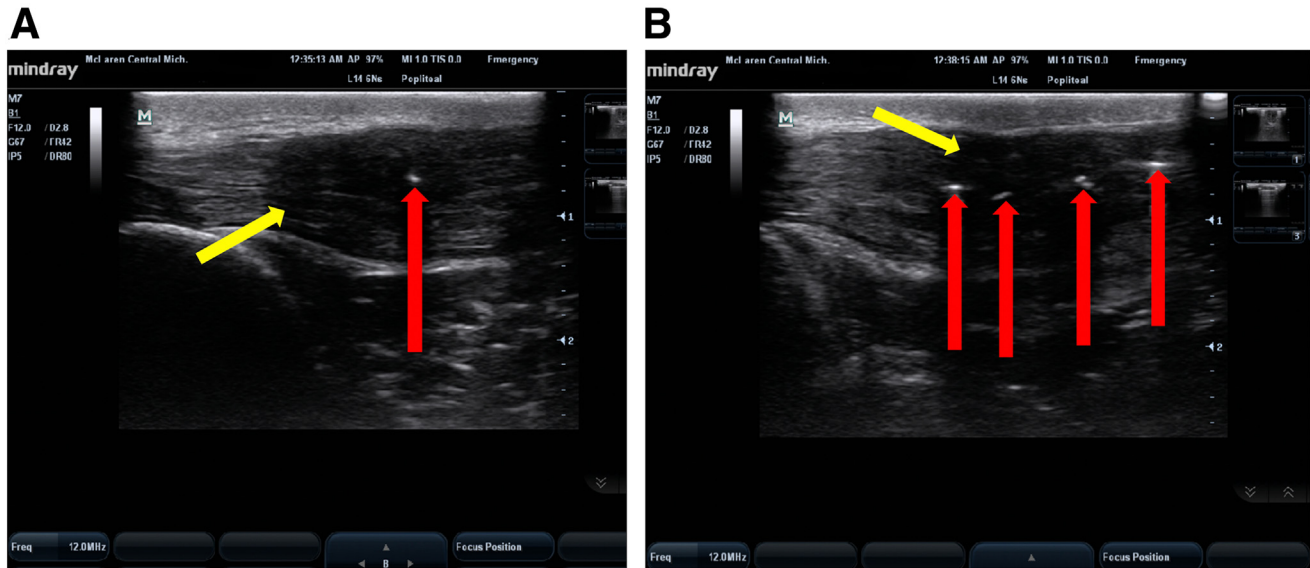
Long-axis ultrasound intraoperative ultrasound imaging of Percutaneous Achilles Repair System (PARS) needle (red arrows) placement through the Achilles tendon (yellow arrow). The ultrasound probe is positioned over the posterior aspect of the ankle, overlying the Achilles tendon, at the level of the ankle surrounding the Achilles injury. (A) One needle (red arrow) is visualized in the PARS jig system, passing through the Achilles tendon (yellow arrow). (B) Four needles (red arrows) are visualized in the PARS jig system passing through the Achilles tendon (yellow arrow).
